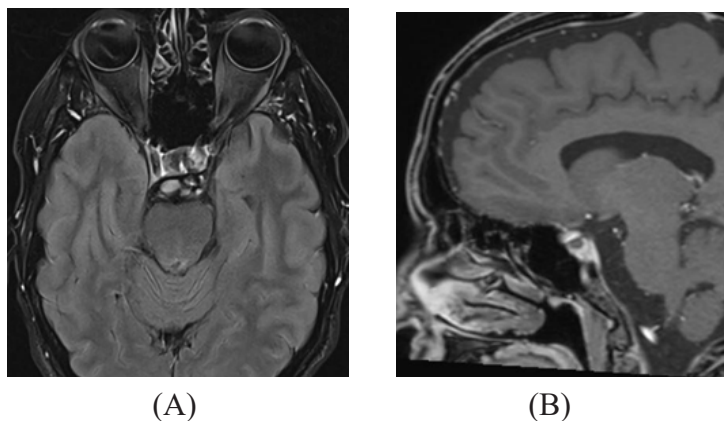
Axial and Sagittal MRI Characterization of a Suspected Meningioma. (A) Axial T1-Weighted Sequence and (B) Sagittal T1-Weighted Sequence Demonstrating a 23-mm Right Frontal Paramedian/Sellar Mass, with Imaging Features Suggestive of Meningioma as the Leading Diagnosis.
